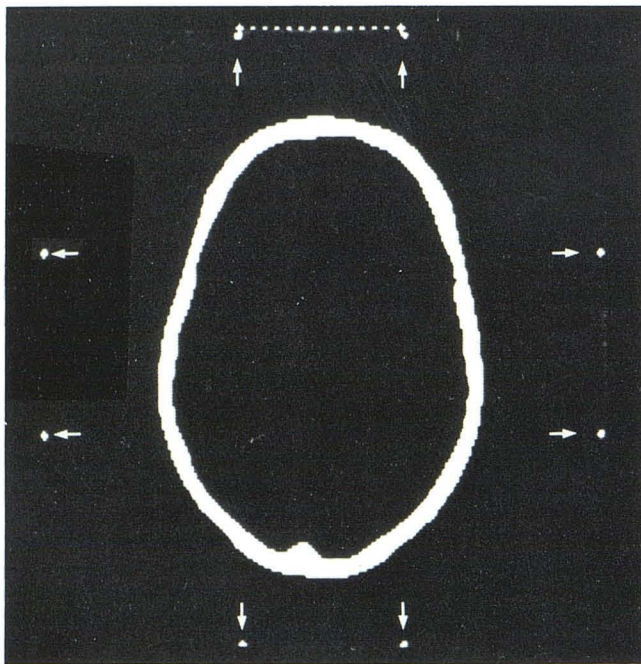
Determination of vertical coordinate: distance between localization wires (arrows) is measured on CT display at 0°, 90°, 180°, and 270°. Measured distance equals vertical coordinate (Z).
